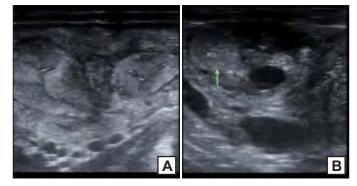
B-mode sonogram of uterus (A) and ovary (B) at day 6 after Cloprostenol injection showing complete evacuation of uterine contents and regression of CL, respectively
